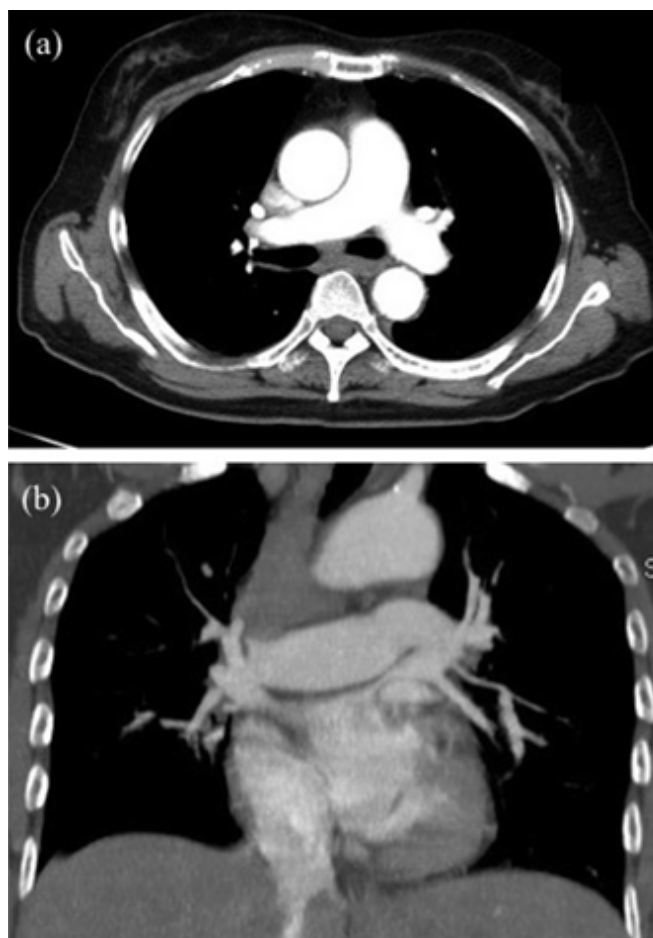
Chest computed tomography (CT) of angiographic phase, showing no signs of pulmonary thromboembolism: Axial series (a) and coronal series (b).
